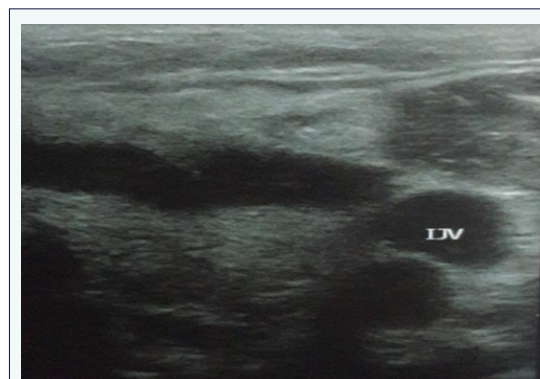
Ultrasound shows that IJV is normal and no thrombosis has seen.
